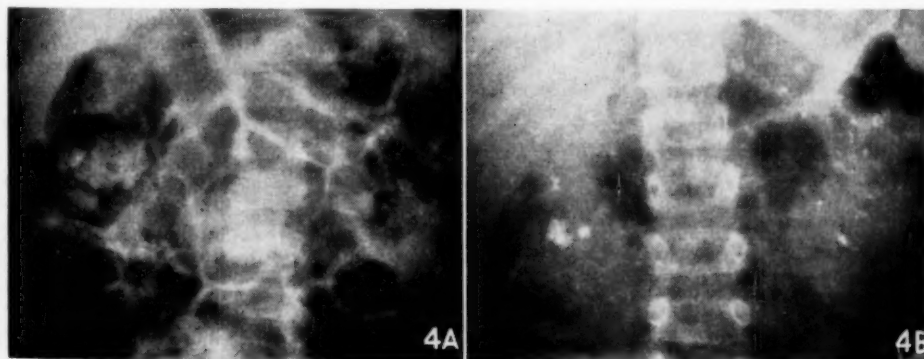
X-rays of abdomen of patient S.S.: A. 1956, showing renal calculi; B. 1960, showing increased calcification.
